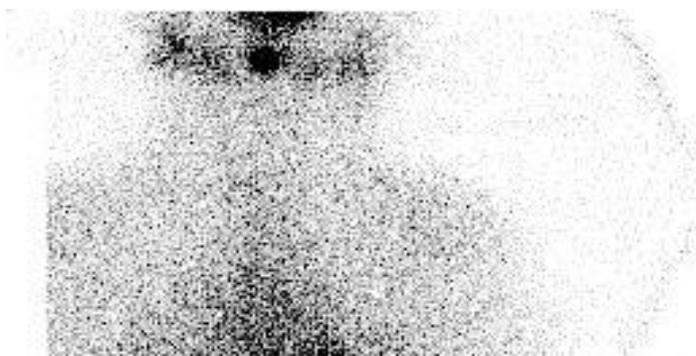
Thyroid scintigraphy aspect
